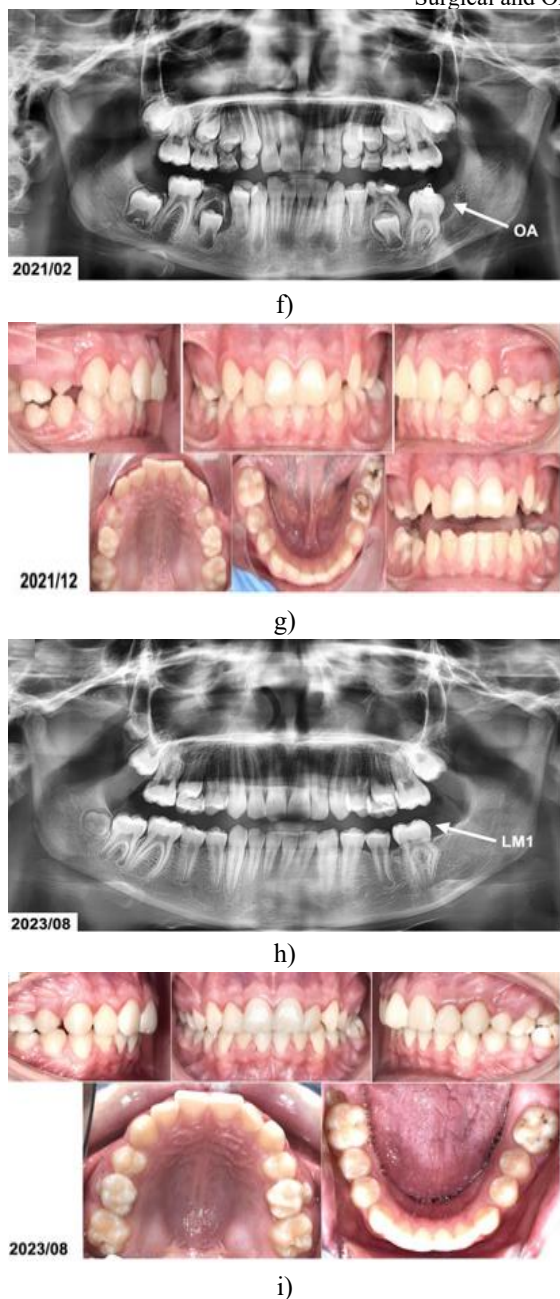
(a) Intraoral view prior to surgical and orthodontic intervention, patient aged 8 years and 10 months. (b) Preoperative panoramic radiograph showing a calcified lesion in the left mandibular molar region consistent with a complex odontoma (OCx). (c,d) Intraoperative photographs during tumor excision, revealing the occlusal surface of the unerupted mandibular left first permanent molar (LM1). Patient aged 8 years and 11 months. (e) Panoramic radiograph following tumor removal and bonding of the orthodontic attachment (OA) to the impacted molar. (f) Radiograph one year post-surgery, demonstrating the orthodontic attachment in place and initial occlusal movement of the tooth. Patient aged 10 years and 1 month. (g) Clinical view of the spontaneously erupted mandibular left first molar after removal of the orthodontic button, patient aged 10 years and 11 months. (h,i) Panoramic radiograph and intraoral photograph four years post-treatment, showing complete eruption of the molar and its position in the dental arch. Patient aged 12 years and 7 months.
